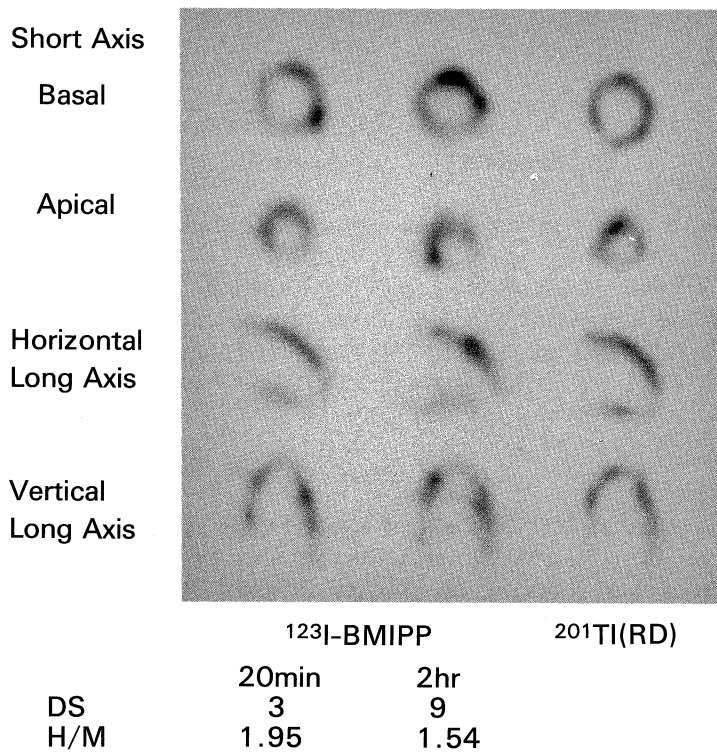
Case 1 (APH type) SPECTs using ¹²³I-BMIPP and ²⁰¹Tl
